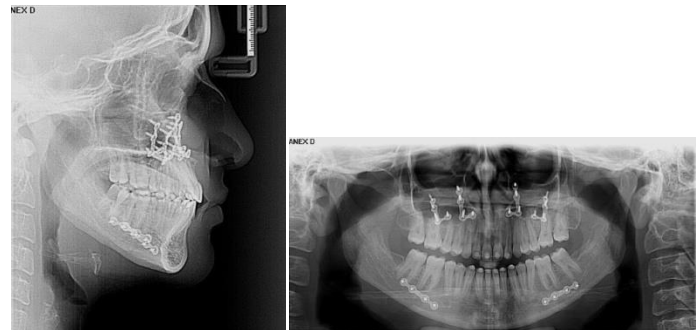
a-Post-treatment lateral cephalogram and 11 b-Post-treatment Orthopantomogram.
